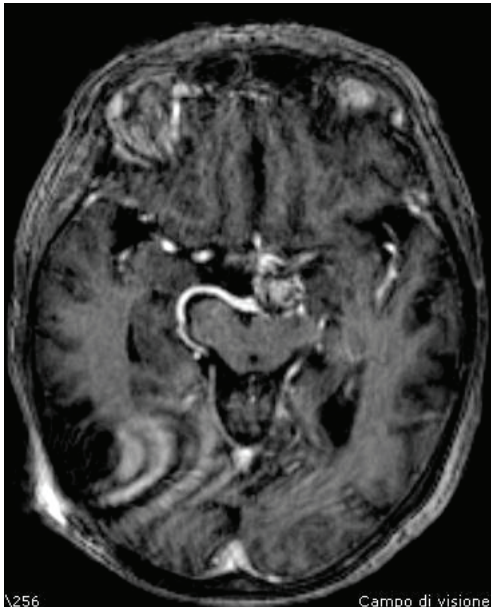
a) T1-weighted image in 2017. The enhancement inside the Aneurysm is the sign of inflammation; b) T1-weighted image in 2020. Strong reduction of the enhancement inside the Aneurysm and strong improvement of neurological symptoms
